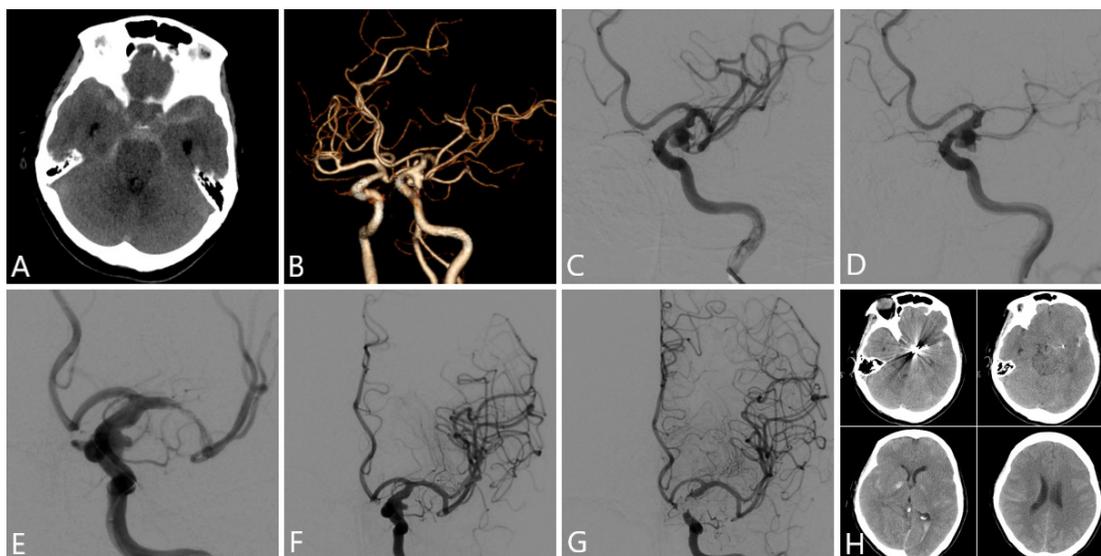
Images of case1. A: The emergency head CT scanning showed subarachnoid hemorrhage in the suprasellar cistern with a modified Fisher score of 3. B: The CT angiography displayed a anterior communicating aneurysm about 5mm*6mm in size. C: Cerebral angiography revealed a aneurysm at the C6 segment of right ICA. D and E: During positioning of the guiding catheter, the middle cerebral artery was not visualized anymore, mechanical thrombectomy was performed with solitaire FR stent. F: After mechanical thrombectomy, the middle cerebral artery was completely recanalized. G: The aneurysm was successfully treated with simple coiling. H: No obvious cerebral infarction was found in the head CT 5 days after the endovascular treatment.
